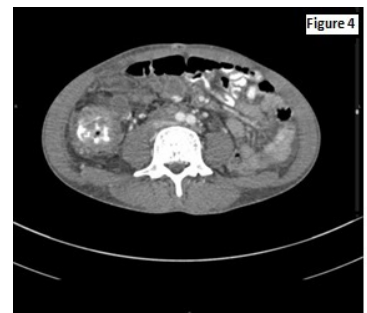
CT abdomen showed circumferential bowel thickening and ascites.
